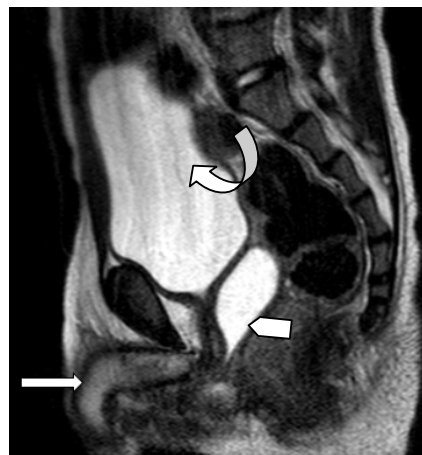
Sagittal T2W MRI showing phallic structure (arrow) which was enlarged clitoris, fluid filled distended uterus (arrow head) and fluid filled urinary bladder (curved arrow).
